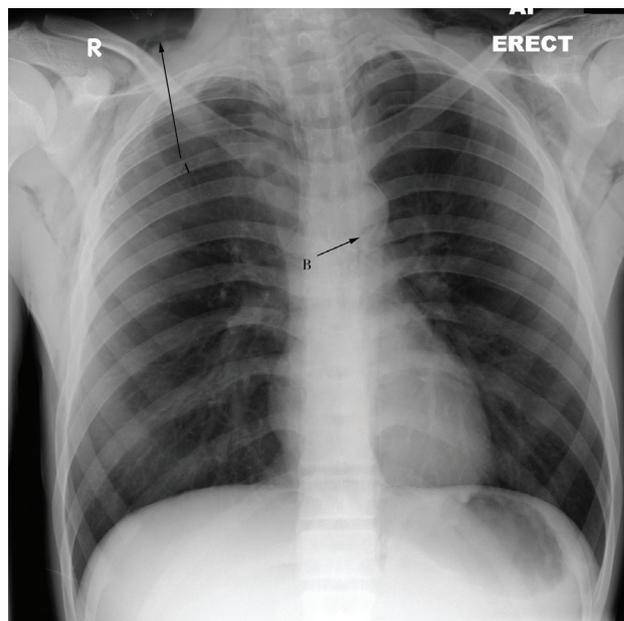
Chest Xray showing subcutaneous emphysema (arrow A) and pneumomediastinum. (arrow B)
